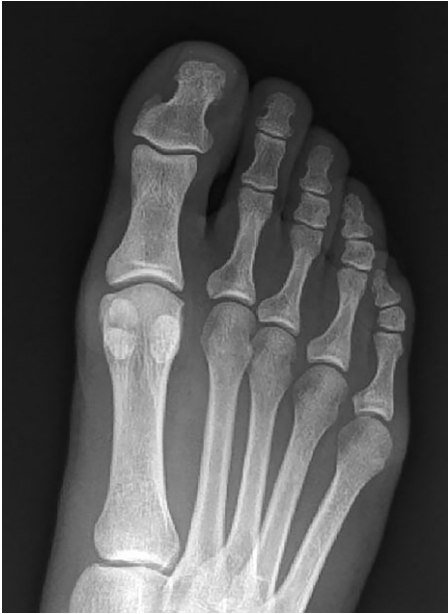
Normal AP radiograph of the right foot. It demonstrates the larger size of the medial sesamoid compared with the lateral sesamoid and it sits more distal. The medial hallux sesamoid is frequently bipartite.
